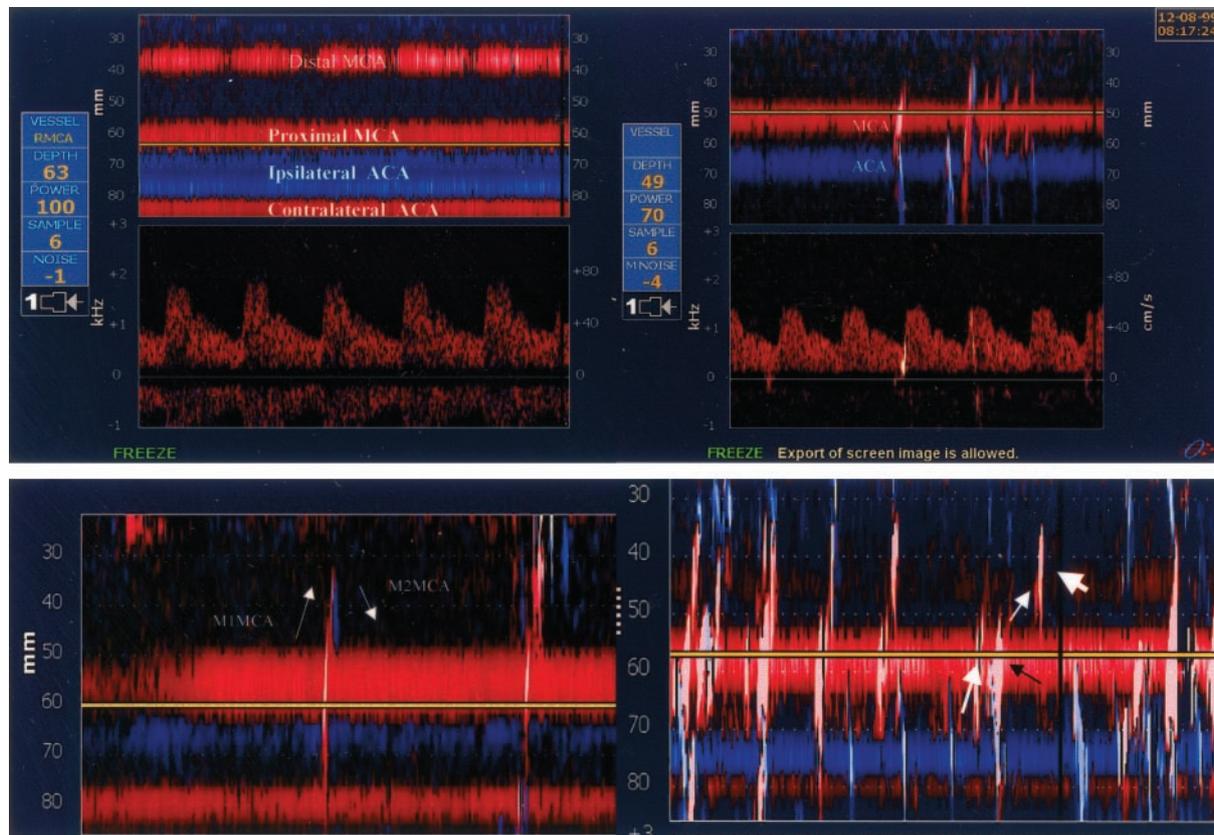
Panel TCD 100 mol/L displays. a, Power M-mode display of the middle cerebral artery at depths of 32 to 58 mm. This represents the entire signal through the ultrasound beam. The yellow line is the specific depth of 41 mm that can be chosen to display a single gate spectral waveform. b, Single-gate spectral TCD waveform at depth 49 mm showing 2 emboli simultaneously appearing in MCA and ACA on M-mode display but only MCA embolus seen on spectral TCD. Emboli counted when track has traversed proximal depth (ie, 50 to 60 mm MCA or 60 to 70 mm ACA) of high signal intensity. c, Patterns of embolic tracks on PMD, which can give an impression of 2 or 3 emboli where in reality only a single microbubble signal exists. d, Thin white arrow shows path of embolus traveling in and out of ultrasound beam. Emboli exits path of ultrasound beam and re-enters it distally. Based on criteria only signature at proximal depth with high intensity would be counted embolus (thin black arrow). The embolus track (thick white arrow) would not be counted.
